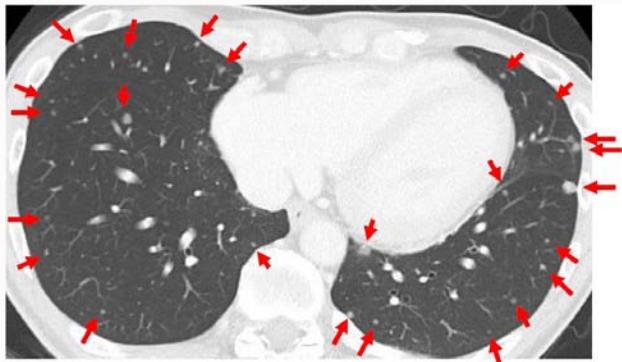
Chest Computed Tomography (CT) revealed the presence of multiple well-demarcated solid nodules of from 0.5 cm to 2 cm in diameter in both lungs.
